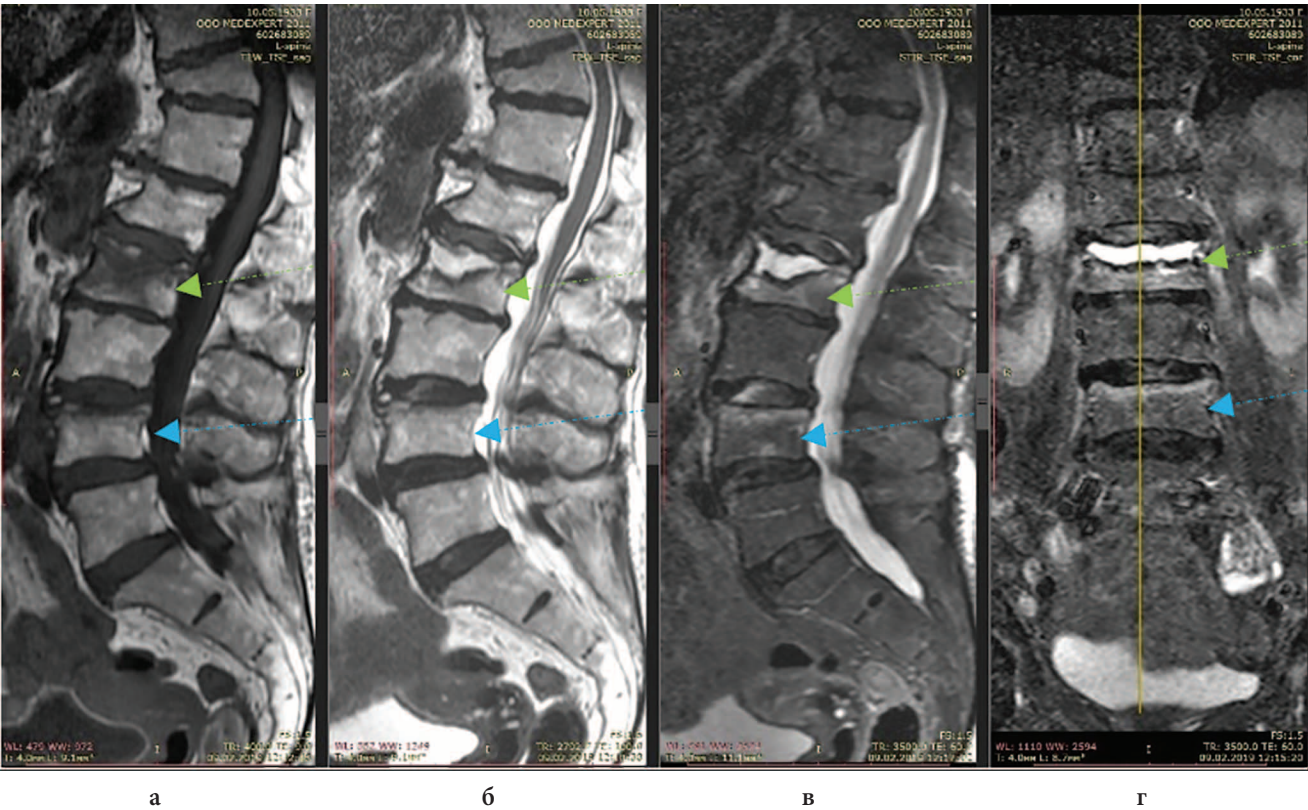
MRI of the thoracic spine 3.5 months after the fracture. Signs of fracture consolidation and disappearance of bone edema: increased signal intensity from the body in T1 WI, iso-intense or slightly hyperintense signal from the body in T2 WI, iso-intense signal from the vertebral bodies in STIR mode as a reflection of the of edema resolution and replacement of this area with adipose tissue of the bone marrow. Regression of bone edema of the Th10 vertebra (blue arrow), the fracture did not develop, the vertebral body is not deformed
